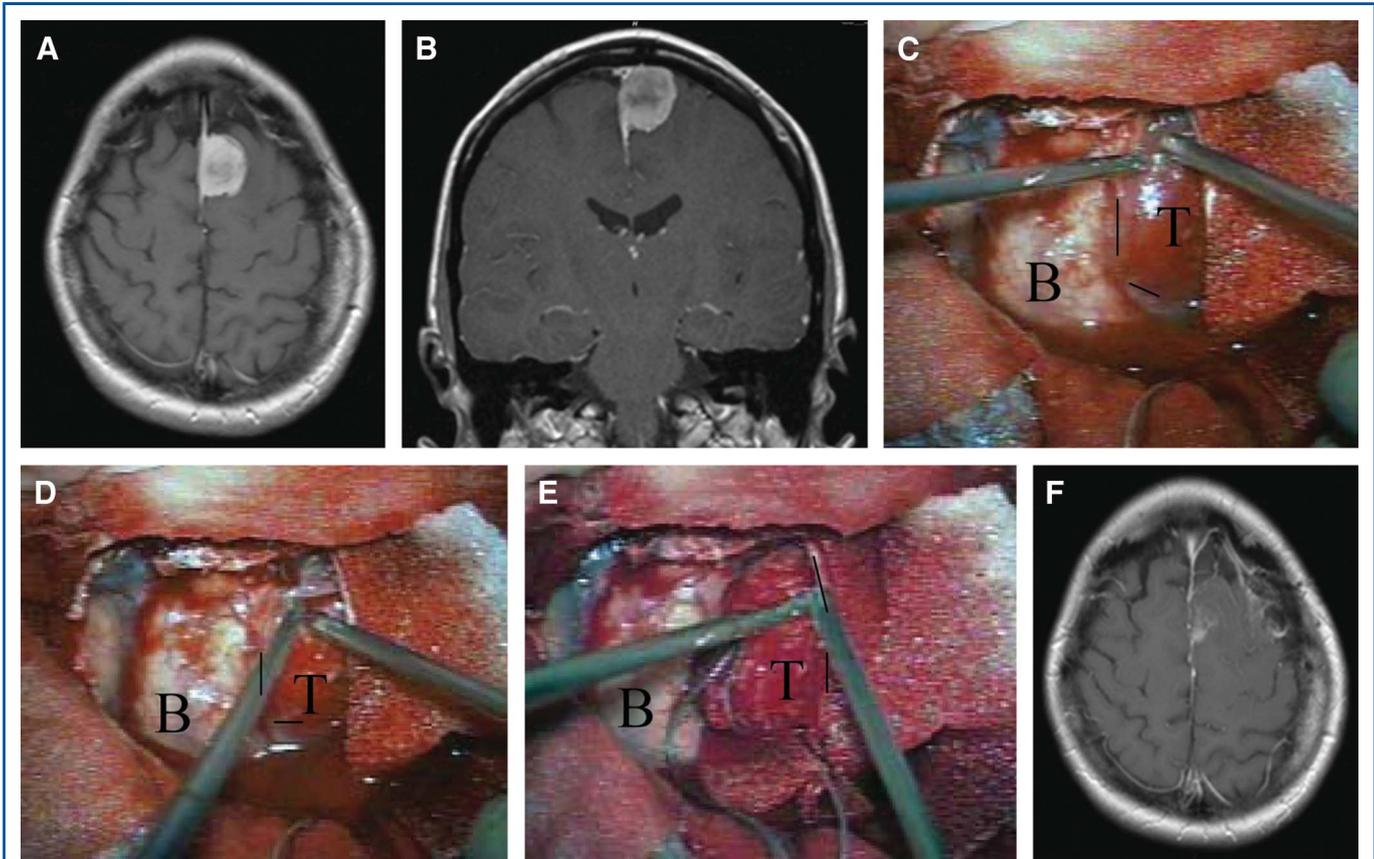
Circular tumor dissection of a falx meningioma using water jet pressures of 6 bar. Preoperative T1-weighted axial (A) and coronal (B) magnetic resonance imaging (MRI) showing the gadolinium-enhancing mass lesion on the left side of the falx. C-E, separation of the tumor from the adjacent brain. The tumor–brain parenchyma border is maintained precisely exact tumor removal. The suction device is held in the left hand and the water jet nozzle in the right hand. T, tumor; B, brain parenchyma; dotted line, tumor-parenchyma border. F, postoperative T1-weighted gadolinium-enhanced axial MRI showing the tumor resection without evidence of remnant tumor mass.
